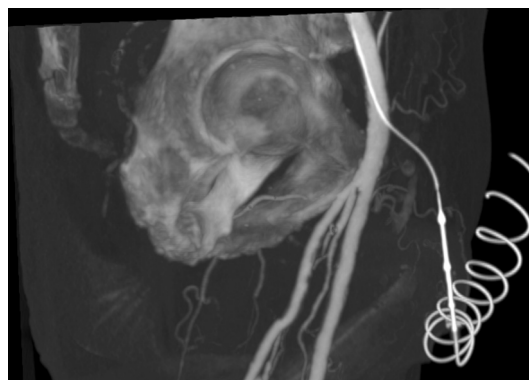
MPR-reformat showing the contrast injection site at s-CTA. A 4 French \times 7 cm micro-puncture catheter has been inserted into the common femoral artery, and is connected to the contrast injector extension tube.
